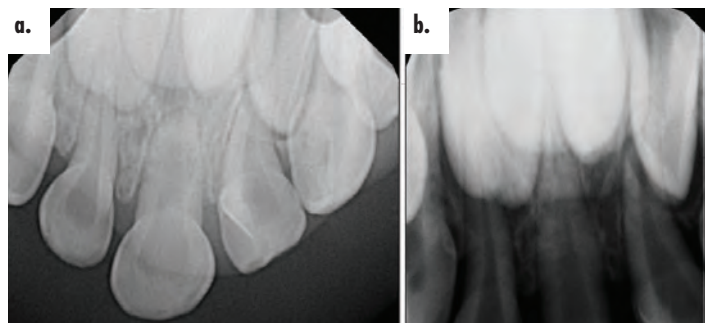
Periapical radiographic images of patient in Case 1. Radiographs emphasize characteristic anatomy of primary solitary median maxillary central incisor. Talon cusp on tooth #G is also readily appreciated (a). Developing succedaneous SMMCI with similar anatomy to primary SMMCI can be appreciated between two unerupted permanent lateral incisors in addition to conical supernumerary tooth distal to permanent left lateral incisor (b).
